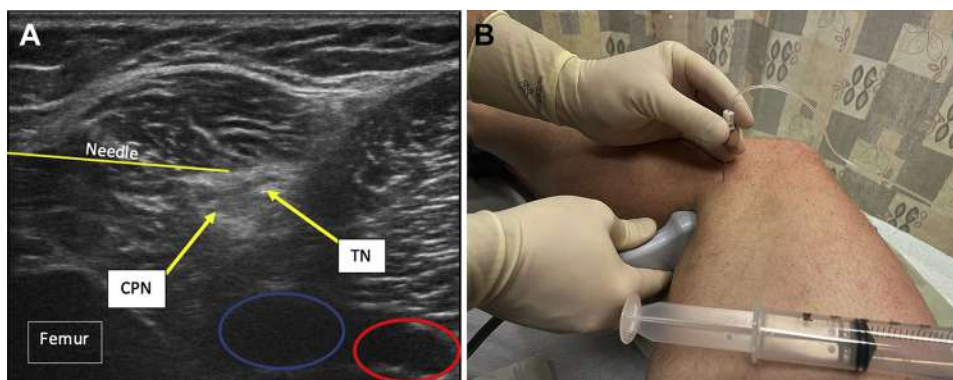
(A) The image on the left shows the ultrasound anatomy of the left sciatic nerve just above the popliteal fossa at the beginning of the sciatic nerve bifurcation into the tibial nerve and common peroneal nerve. Just deep and medial to the tibial nerve and common peroneal nerve are the popliteal vein and artery, circled in blue and red, respectively. (B) The patient is shown in the right lateral decubitus position. An ultrasound-guided sideline popliteal sciatic nerve block is performed with the needle entering from a lateral approach in plane with the ultrasound probe, with local anesthetic deposited around the nerve.
